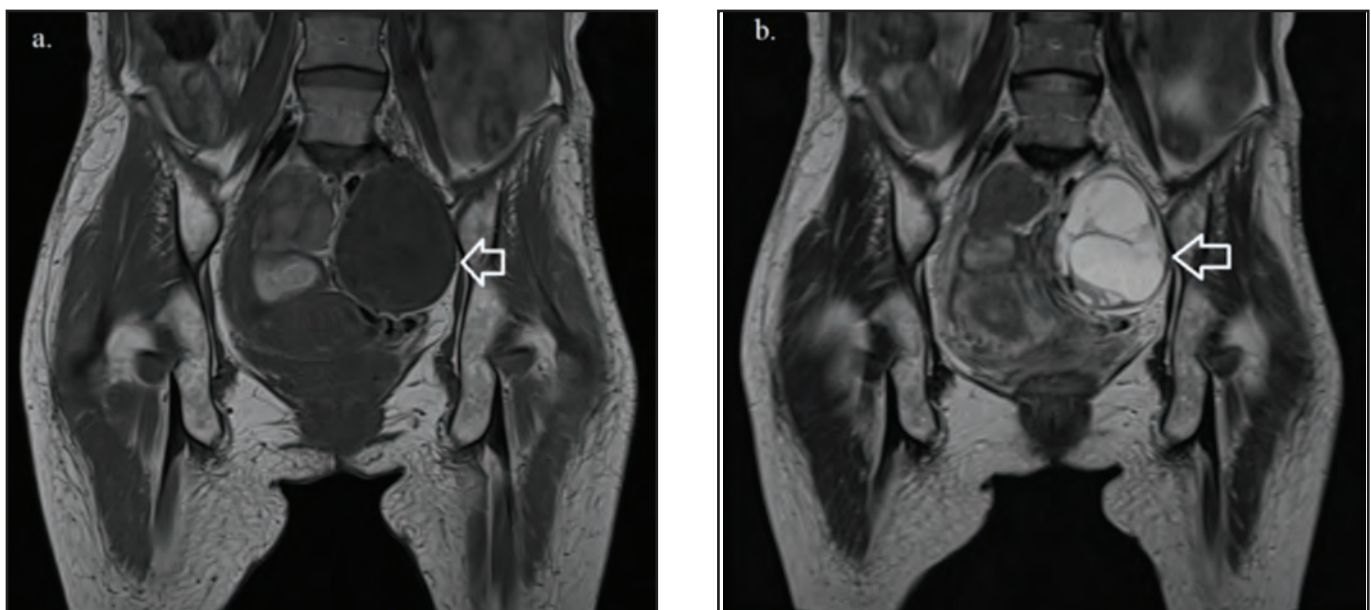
MRI shows well-encapsulated predominantly cystic mass. (a) Heterogeneously hypointense lesion with T1W sequence (arrowed). (b) Heterogeneously hyperintense lesion with T2W sequence (arrowed).
